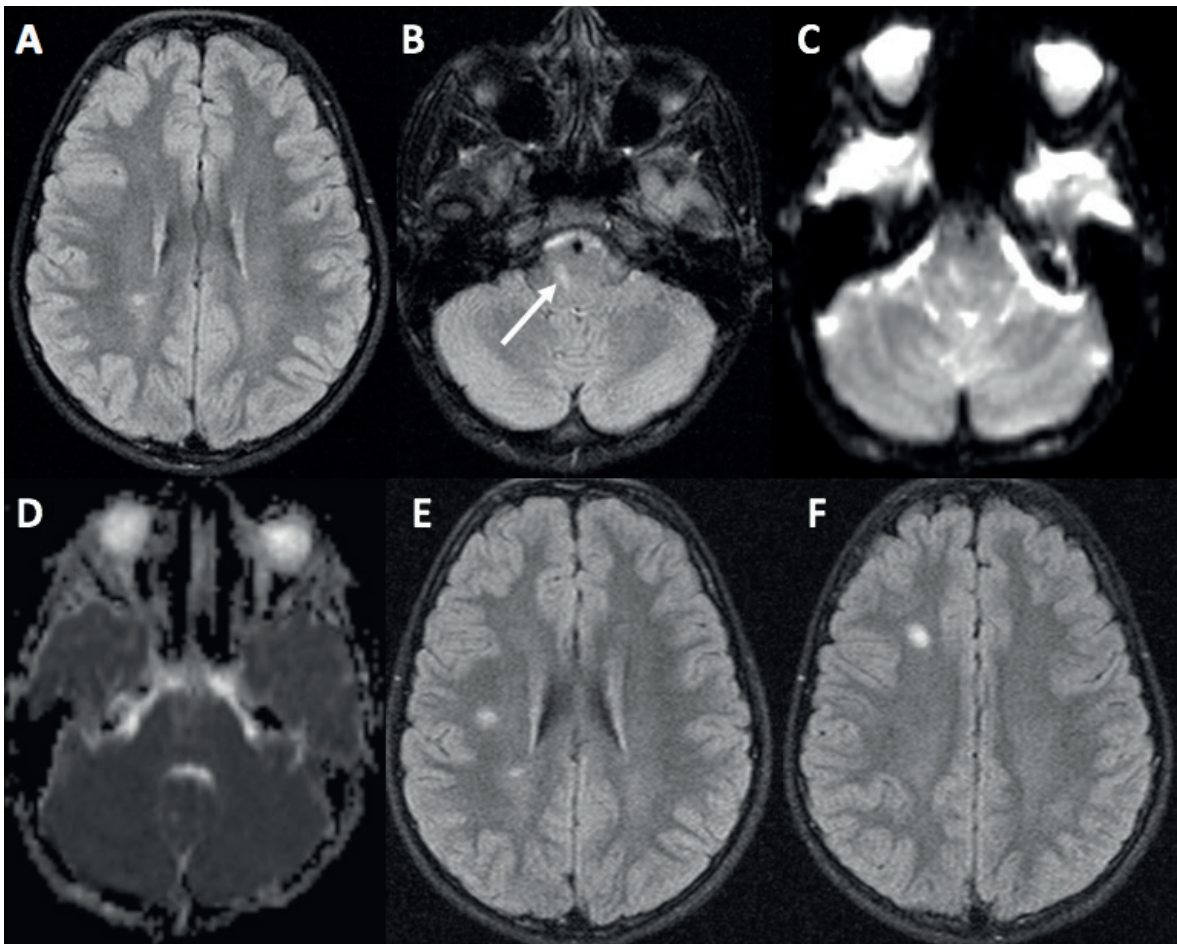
The brain magnetic resonance imaging (MRI) of an 11-year-old boy presenting with diplopia who was diagnosed with MS 1 month after the first event. (A, B) Baseline axial FLAIR MRI of the brain revealing the hyperintense lesions in the periventricular white matter and brainstem (white arrow). (C, D) Diffusion-weighted imaging and ADC showing high signal intensity resembling stroke in the brain stem. (E, F) One month after the first event, FLAIR MRI showing new hyperintense lesions in the periventricular white matter.
